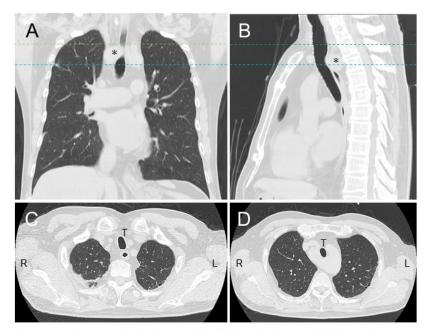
(A) Computed tomography (CT) image, coronal view. Unusual shadow (*) overlaps trachea. (B) Sagittal view. Space occupied lesion (*) compresses trachea anteriorly. (C) and (D) are transverse planes corresponding to levels of green and blue dotted lines respectively in the coronal (A) and sagittal (B) views. Narrowing trachea decreased in the coronal diameter. L, left side; R, right side; T, trachea.
